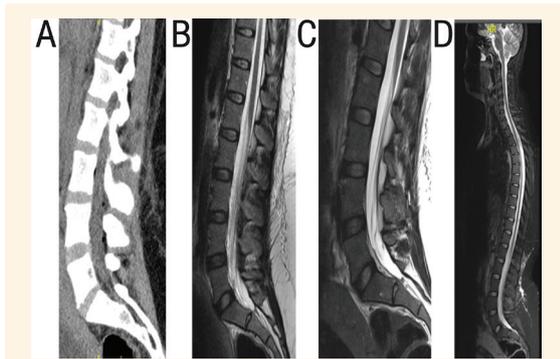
Imaging of the spine of a 29-year-old female patient with a paraparetic variant of Guillain-Barré syndrome. A: Computed tomography scan of the lumbosacral spine showing an absence of hyperdense signals. B & C: Magnetic resonance imaging (MRI) scans of the lumbosacral spine (B) on the day of symptom onset and (C) one week later showing no acute infarction or herniated disc. D: MRI of the whole spine was grossly unremarkable.
